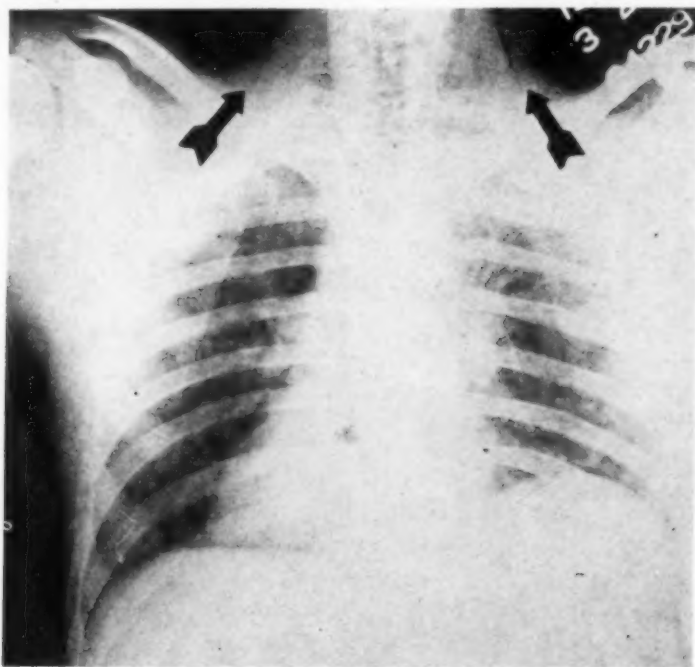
Roentgenogram on March 25 shows reexpansion of the right lung with the presence of subcutaneous emphysema on both sides of the neck.
